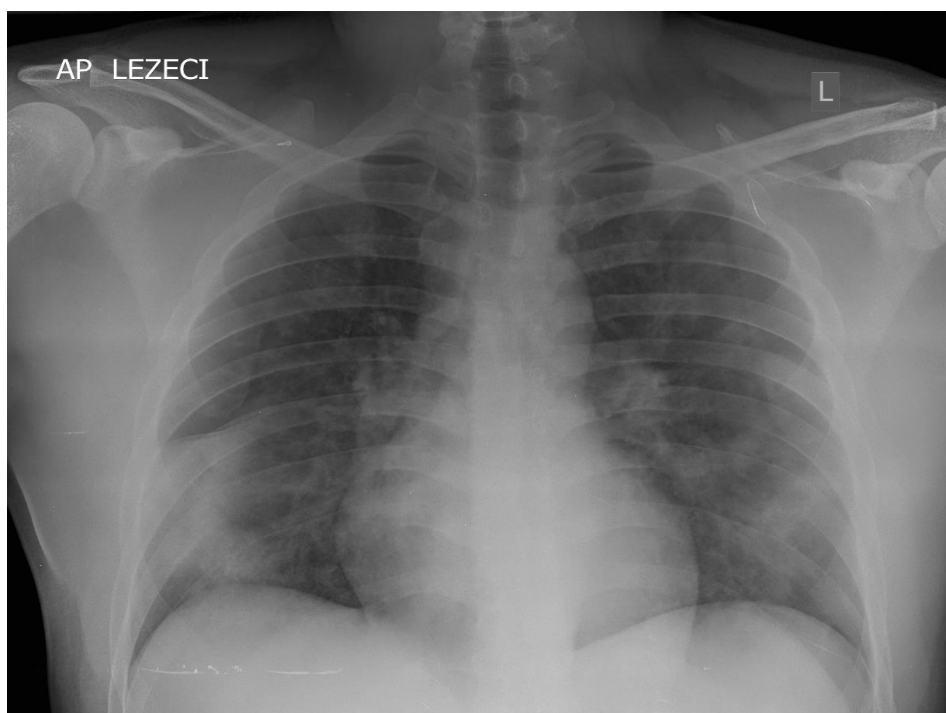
Chest radiograph showing bilateral pneumonia
